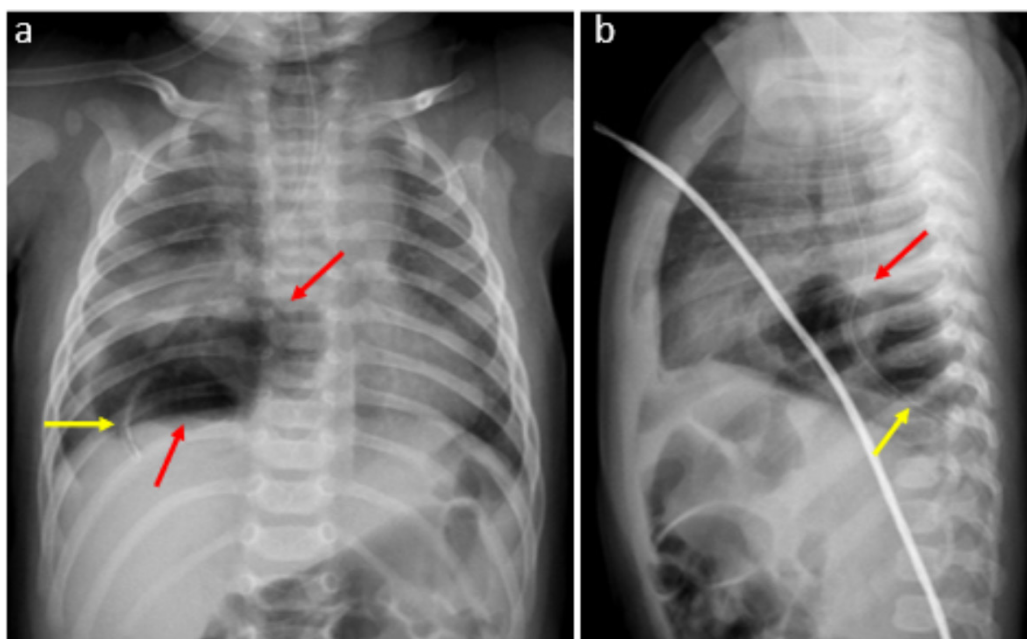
a, b. Posterior-anterior lung (a) and lateral lung (b) radiographs show that the stomach gas is not in its normal position and the air-containing gastric structure (red arrows) in which the nasogastric tube extends (yellow arrow) herniates into the right hemithorax
